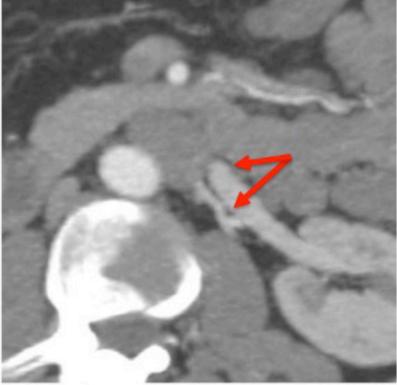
(a) Coronal CT demonstrating left sided IVC (white arrow) (b) axial view demonstrating two renal veins draining into the left sided IVC (red arrow). An open procedure was performed to resect the left kidney.
